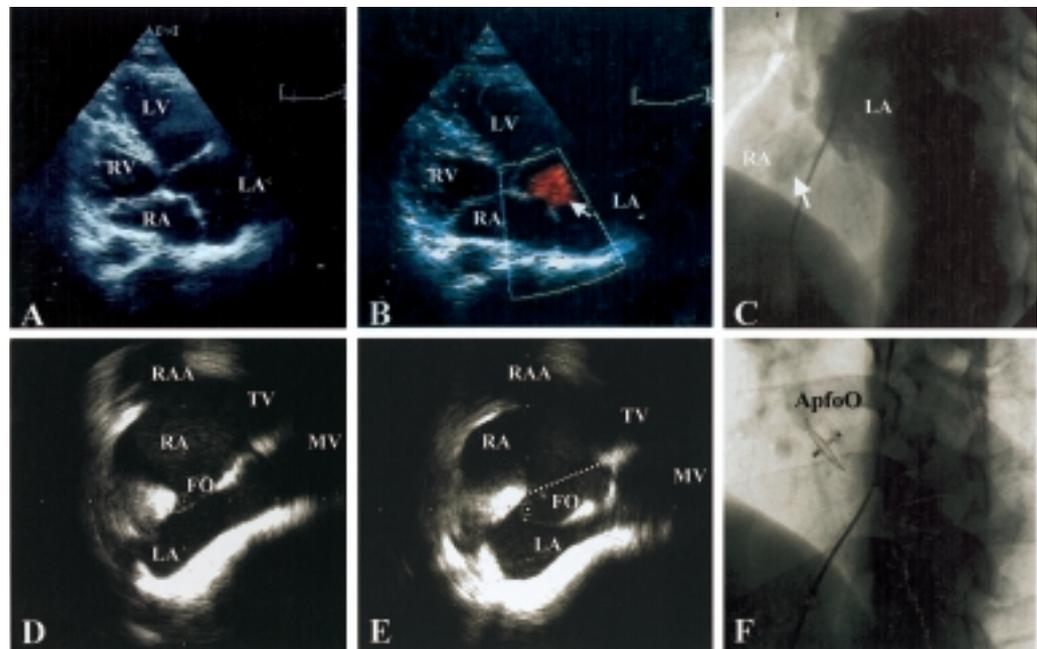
A, B: 4-chamber axial view during transthoracic echocardiography. A 1.2 cm interatrial communication (arrow) with shunting was clearly displayed, suggesting an atrial septal defect. C: right upper pulmonary vein angiography in the right anterior oblique view. The arrow points out a jet of contrast medium which partially opacifies the right atrium (RA). D, E: apex up 4-chamber planes during intracardiac ultrasound imaging, displayed in a computed tomographic scanning format (left-sided structure displayed to the viewer's right, anterior-sided structure on the top, and so on). The fossa ovalis (FO) is viewed as a continuous structure without a significant defective area and its bulging, with respect to the ideal line of the interatrial septum was evident during the cardiac cycle (D: diastole; E: systole). The other structures are: the left atrium (LA), the mitral valve (MV), the RA, the right atrial auricle (RAA) and the tricuspid valve (TV). F: successful closure using an Amplatzer 25 mm patent foramen ovale occluder (ApfoO). LV = left ventricle.
